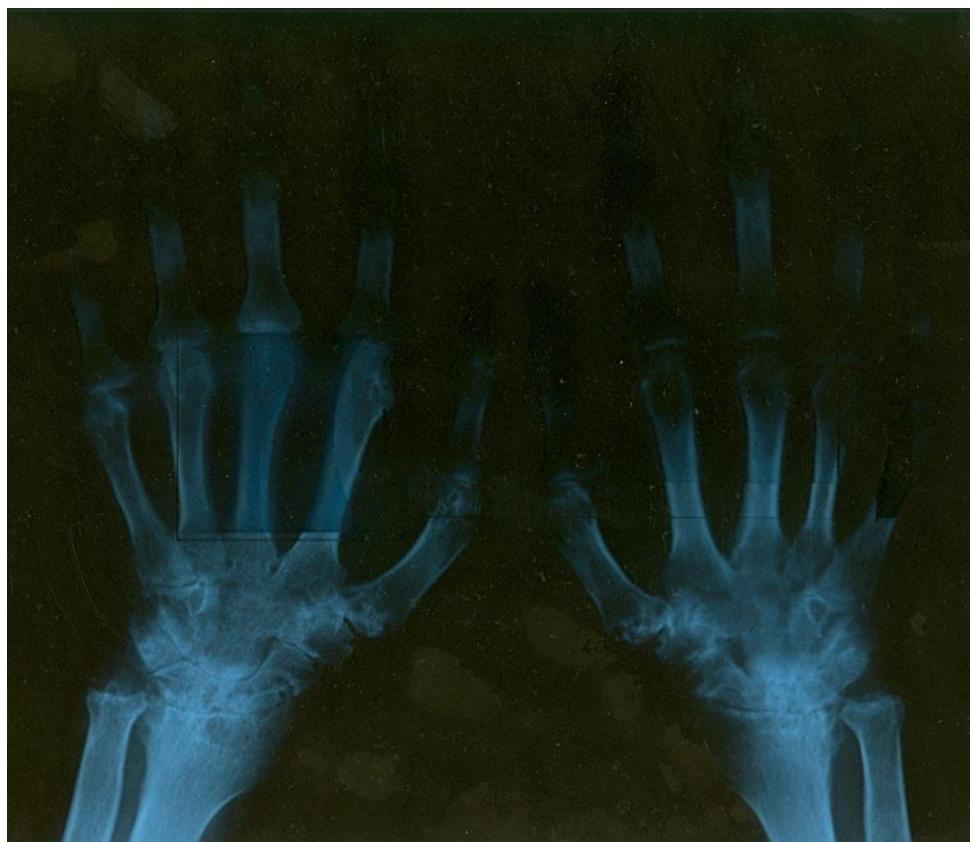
The corresponding radiograph demonstrates: osteoerotive carpal injuries, subchondral geodes and periarticular erosions at the level of MCF and VET joints intercarpal joints space narrowing, MCF and IF.
